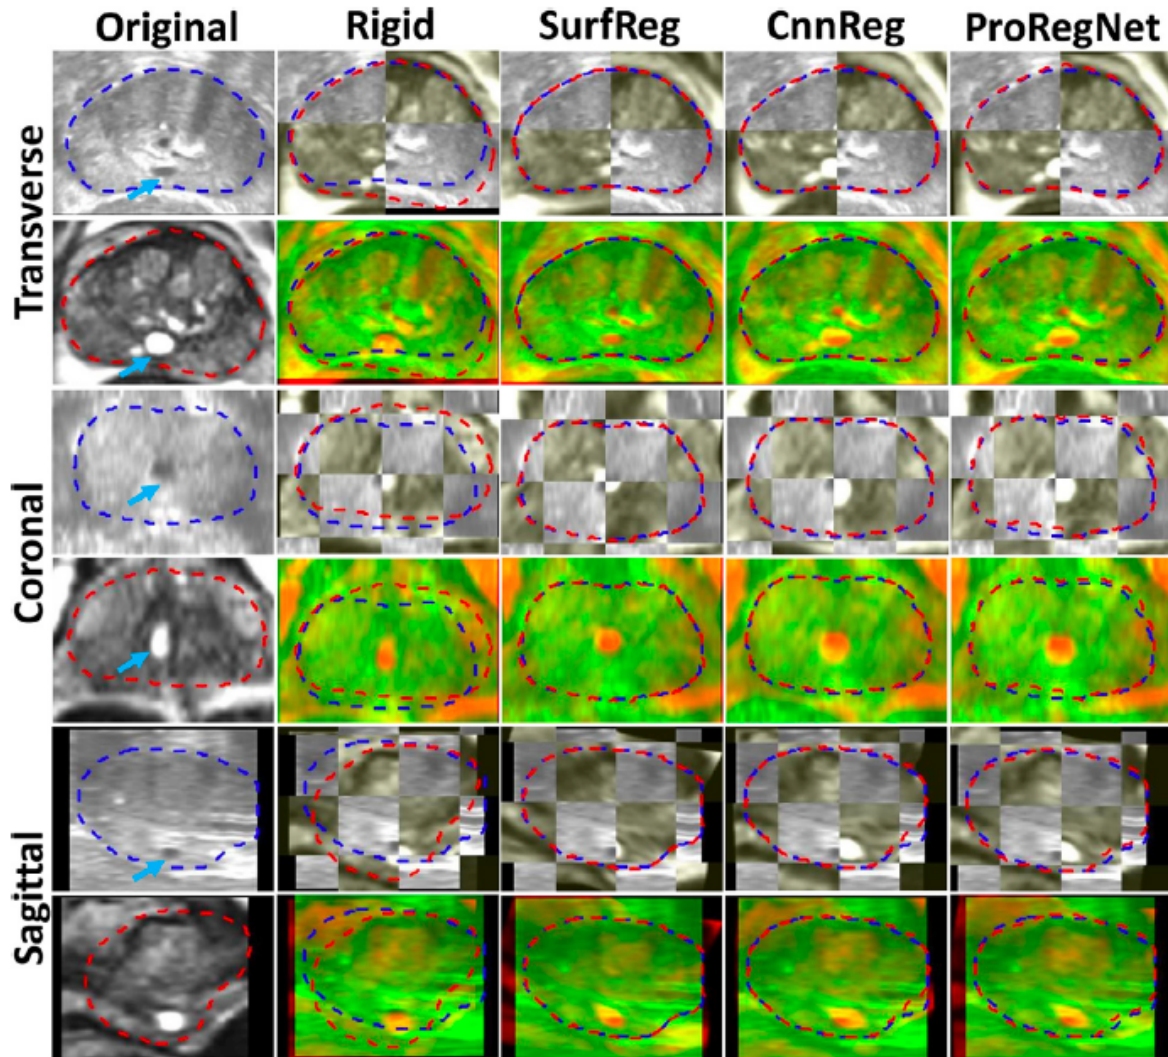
Example image slices from one case. Results are shown in the transverse, coronal and sagittal planes. First column shows the original TRUS and MR images. Second column shows the images after rigid registration in checkboard and red-green fusion. Third, fourth and fifth columns show
